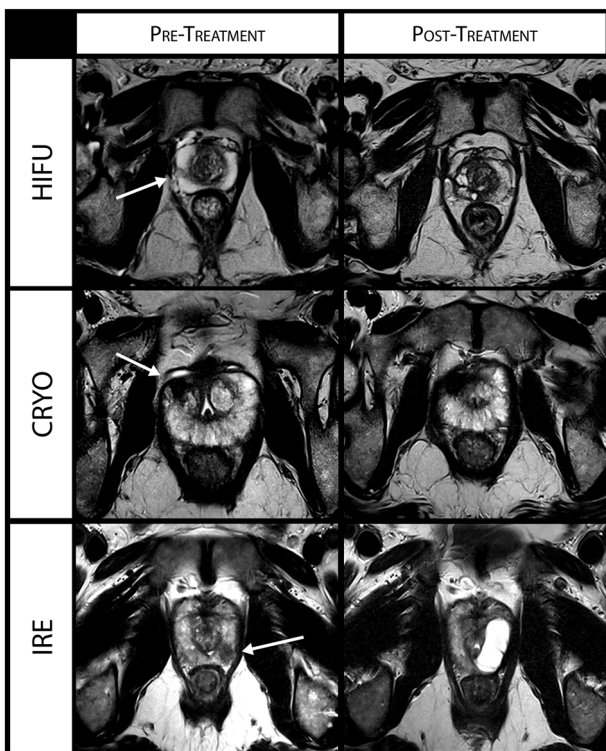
One-year post-ablation MRI changes using different energies. Size reduction of the ablated lobe, scar tissue, fibrosis, midline shift and fluid-filled cavities are the most common findings at MRI after ablation.
